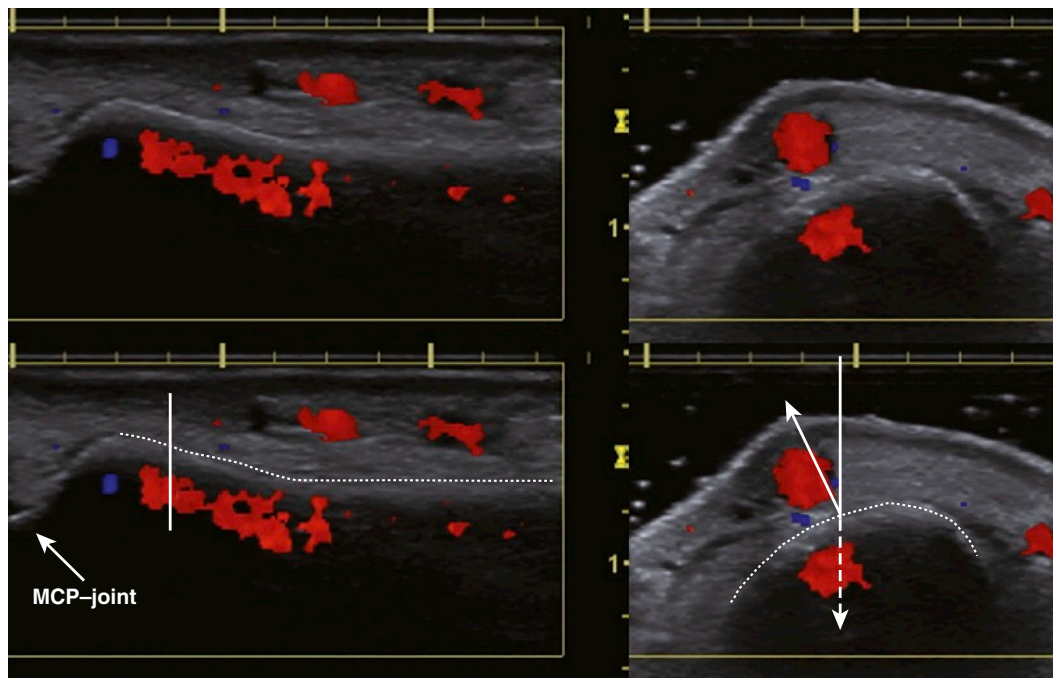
BONE SURFACE AS ACOUSTIC MIRROR. Longitudinal scans (left) show the index finger with the proximal aspect oriented left. The surface of the proximal phalanx (dotted line) acts as an ultrasound mirror. Flow in the dorsoradial digital vein is seen above (true) and below (false) the bone surface. In the proximal half, only the false flow is seen. The vertical line indicates the scan plane used in the right images. Transverse scans (right) show the base of the proximal phalanx. Flow in the digital vein is seen above and below the bone surface (dotted line), which acts as an oblique acoustic mirror. The path of one of the scan lines is shown (arrows). This scan line demonstrates the longitudinal scan plane in the left images and explains why only the false flow is seen there. (From Torp-Pedersen S, Terslev L: *Settings and artefacts relevant in colour/power Doppler ultrasound in rheumatology*. *Ann Rheum Dis* 2008;67:143-149.)
